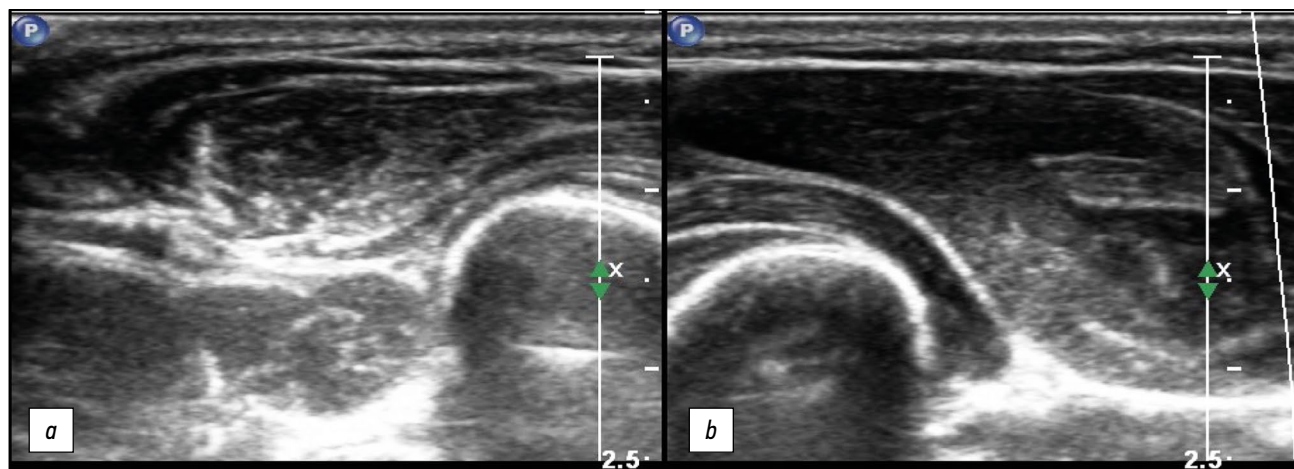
Cross-sectional ultrasound of muscular hypotrophy (a), comparison with the healthy side (b). The muscle volume is reduced with increased echogenicity, and differentiation into fibers is preserved.
